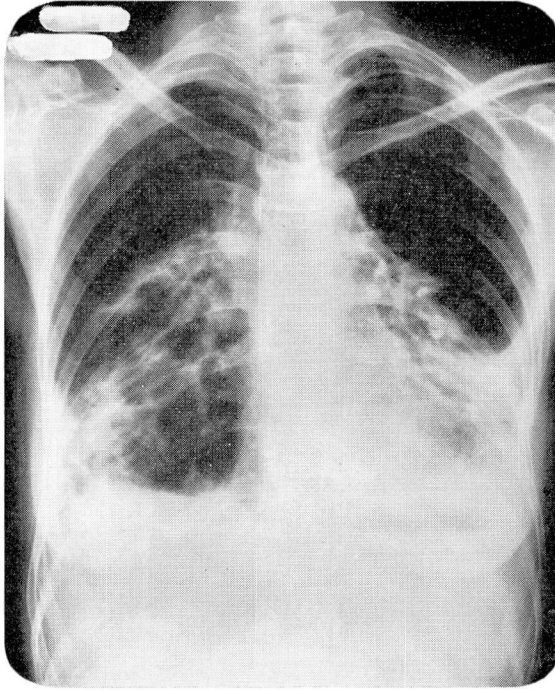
Roentgenogram (eight days before death) shows dense alveolar infiltrate and fibrosis in lower lung lobes.
